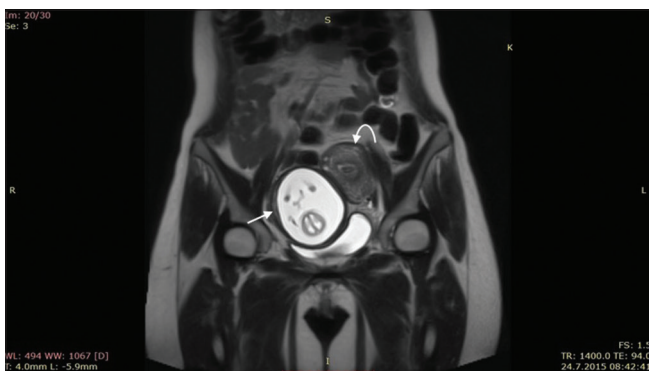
Axial T2-weighted magnetic resonance imaging shows a gestational sac surrounded by thin myometrial tissue on the right (straight arrow) and an empty uterus on the left side (bent arrow). No communication was seen between the uterus and the cavity that contained the fetus, confirming the diagnosis of a rudimentary horn pregnancy
